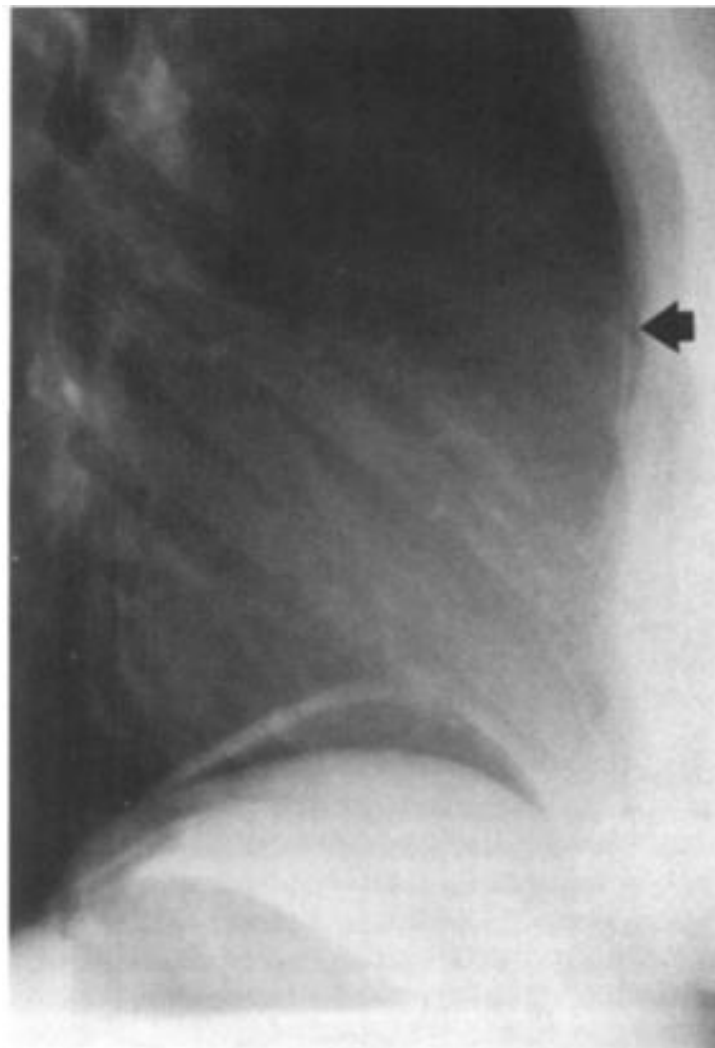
Immediate postoperative chest radiograph demonstrating massive capnopericardium.
